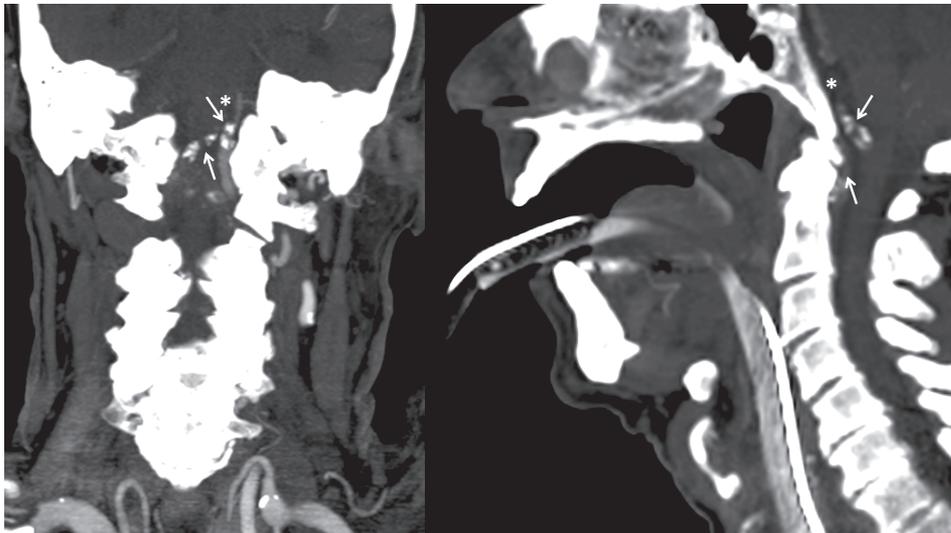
CT angiography showing acute basilar artery occlusion and bilateral vertebral artery occlusion. 77 years old male admitted because of acute vertebrobasilar stroke with rapid progression to coma. CT angiography showing basilar artery occlusion (*) and bilateral vertebral artery occlusion (arrows) with extensive atherosclerosis.
